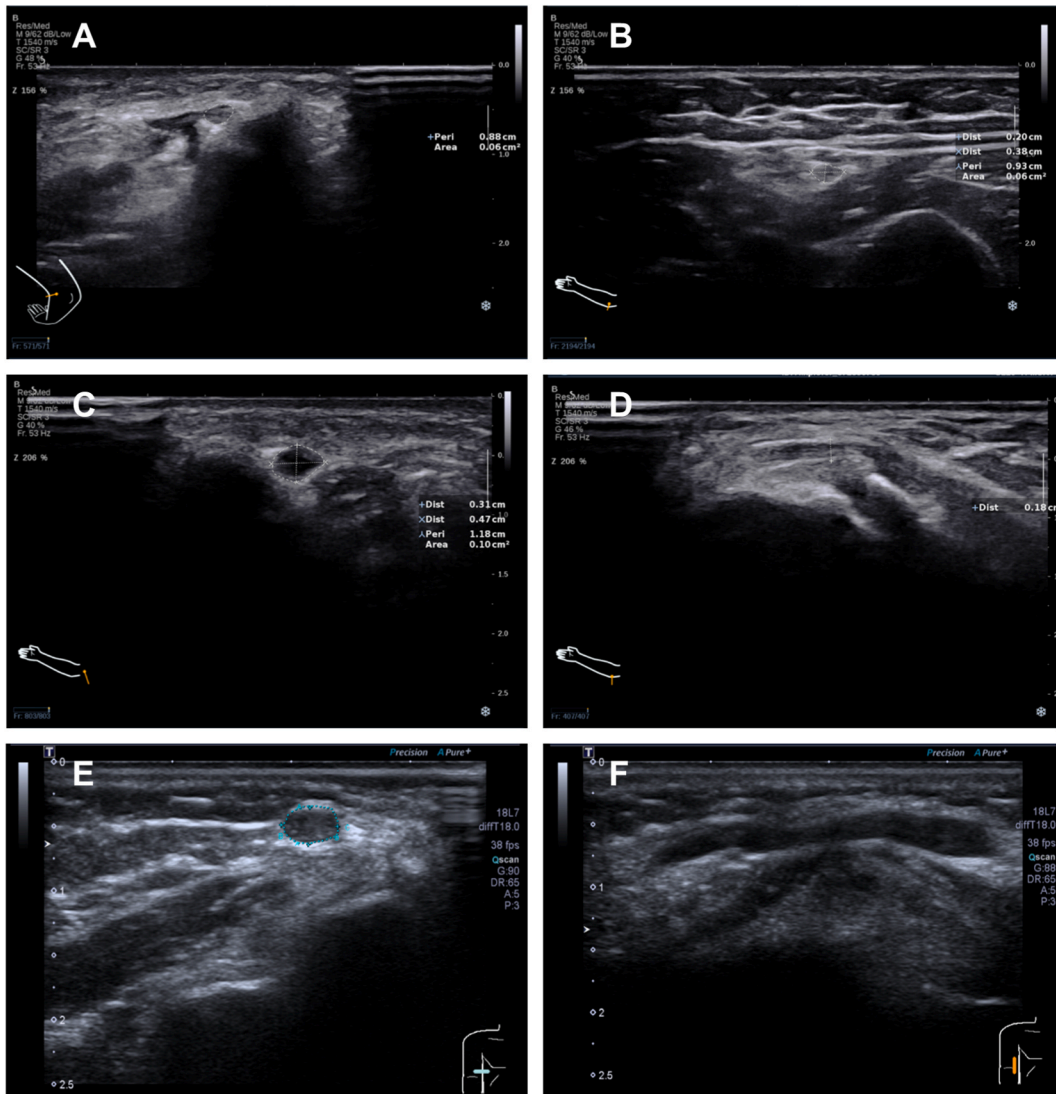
Ultrasound imaging showing the ulnar nerve (A) at the forearm below the cubital tunnel, (B) at the forearm above the cubital tunnel, (C) at the upper arm (transverse section), and (D) at the upper arm (longitudinal section) preoperatively. (E) At the elbow (transverse section), and (F) at the elbow (longitudinal section) postoperatively.
